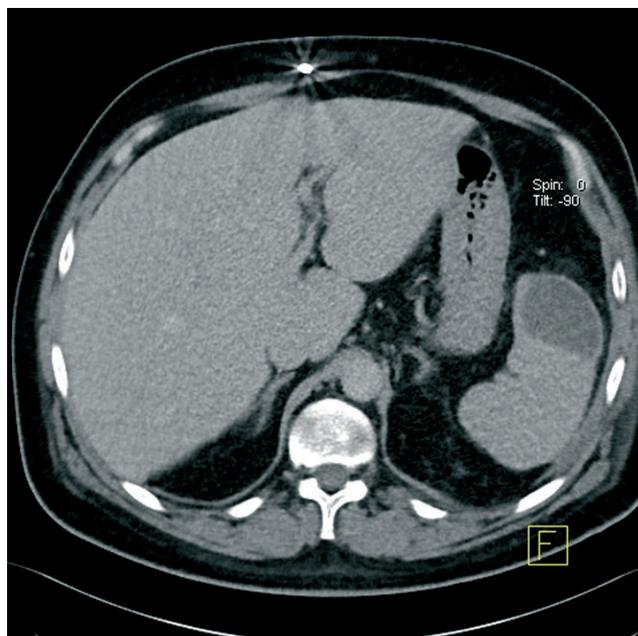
CT - an abscess is seen in the spleen.
